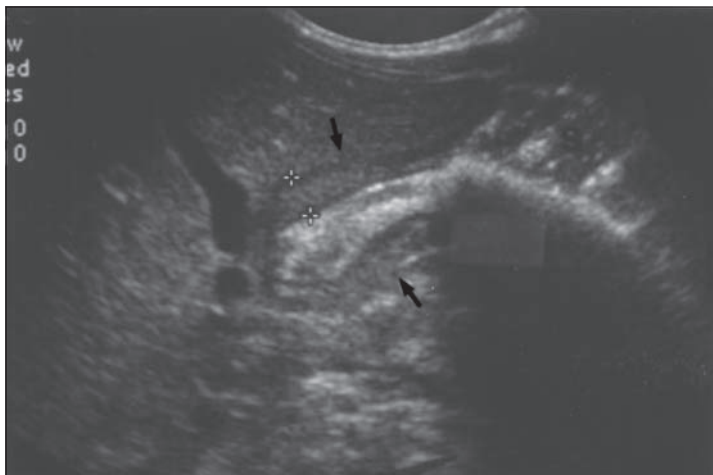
Hypertrophic pyloric stenosis (sagittal view). Focused ultrasound of the right upper quadrant shows an elongated pylorus (arrows) with thickened muscle (x-x = 4 mm). S = Stomach.
